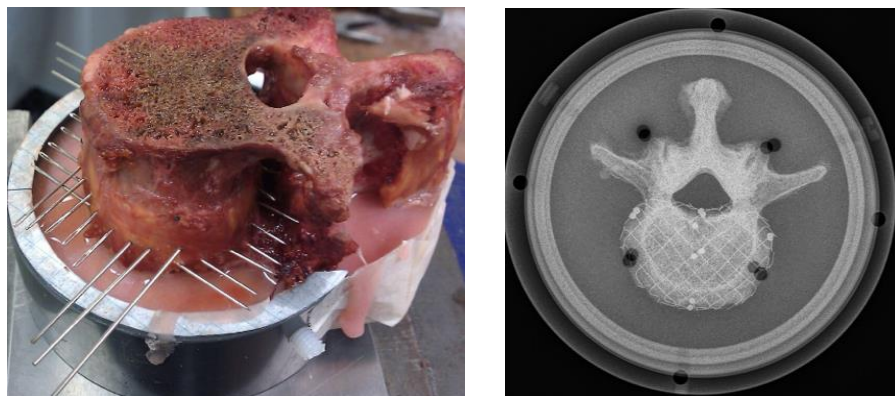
The tantalum wire grid insertion using long needles at 5mm intervals of the mid-transverse plane at 45 degree (left) (Costi et al. 2007) The X-ray radiograph is showing the wire grid and endplate visible radiographic beads from axial view (right) (Amin et al. 2015).
